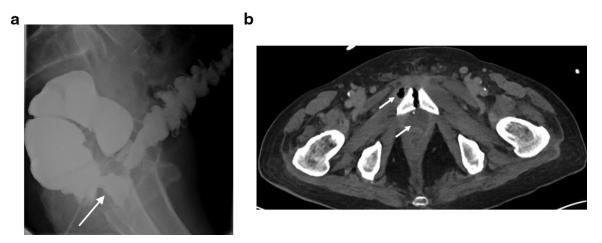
(a and b) A water soluble enema demonstrated extravasation of contrast anteriorly from the rectum consistent with a rectal leak from an injury sustained during surgery. The patient subsequently had a CT scan (12b) which demonstrated a pelvic collection (arrow) with locules of gas extending to and involving the pubic symphysis consistent with secondary osteitis pubis.
